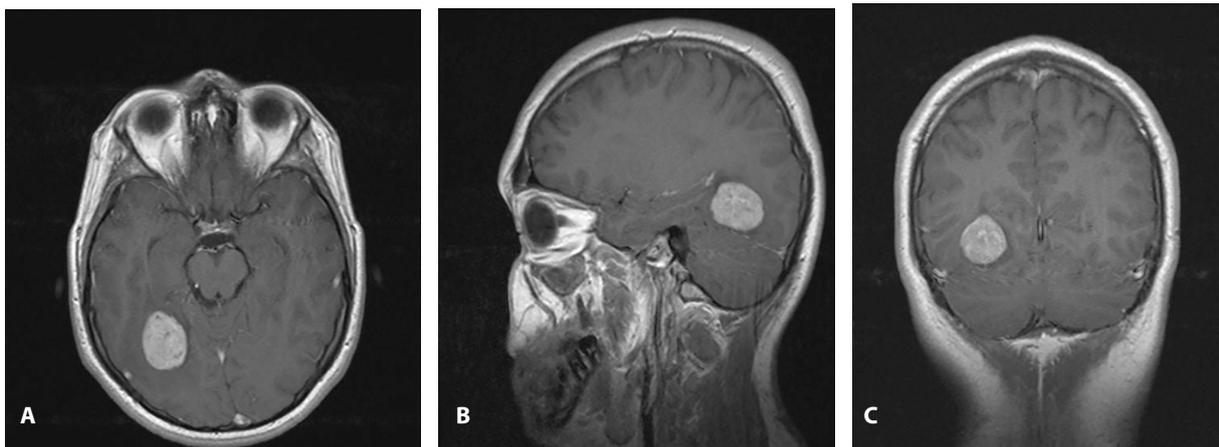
Axial (A), sagittal (B), and coronal (C) MRI showing irregularly round solid expansive and compressive brain lesion in the right temporo-occipital region with contrast uptake (ganglioglioma).
